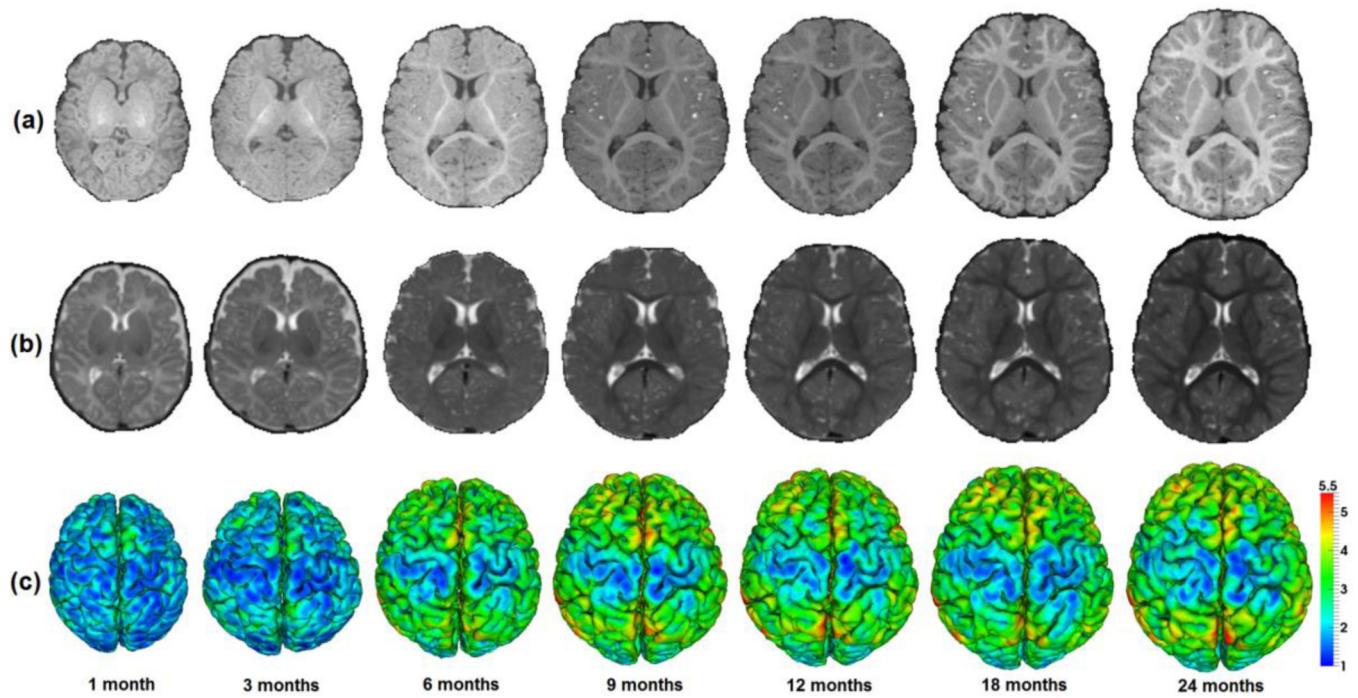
Longitudinal dynamic brain development of an infant in the first 24 months of life. (a) T1-weighted MR images. (b) T2-weighted MR images. (c) Reconstructed outer cortical surfaces, color-coded by cortical thickness (mm).
